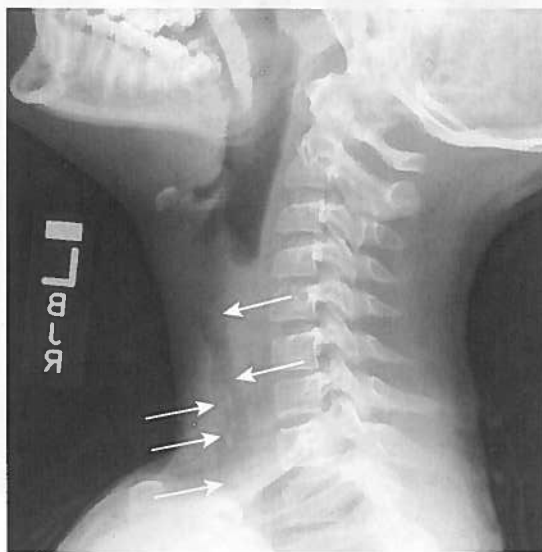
Exudative tracheitis. Lateral radiograph showing irregular plaque-like filling defects and airway wall irregularities (arrows) within trachea. Again, note the normal appearance of the nonthickened epiglottis in this patient.
